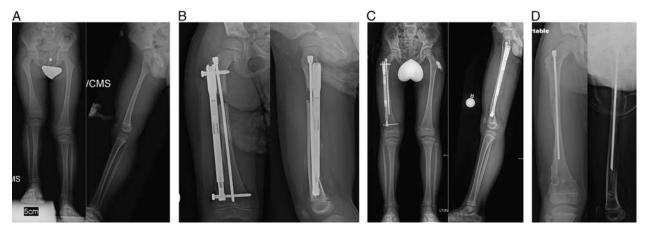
A, Anteroposterior, and lateral standing x-ray of a patient with right congenital femoral deficiency. The diameter of the femoral diaphysis is too narrow to accommodate an intramedullary lengthening nail, although the length of the bone is adequate. The hip is well covered and the knee was stable on clinical examination. B, Gradual (0.75 mm/d) lengthening with an extramedullary trochanteric PRECICE nail over the SLIM rod. C, Anteroposterior and lateral standing x-ray after 50 mm right femur lengthening and consolidation. D, Postoperative anteroposterior and lateral x-ray at the time of removal of an extramedullary femoral lengthening nail. Note the distal metaphyseal channel where the nail was docked into the bone.
